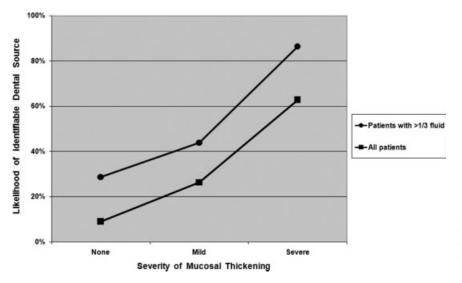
Association between maxillary sinus mucosal thickening and dental source of infection. The likelihood of identifying a dental source of infection radiographically increased with the degree of mucosal thickening. The effect was present even in those patients with substantial amount of fluid, suggesting that mucosal thickening is independently predictive.
